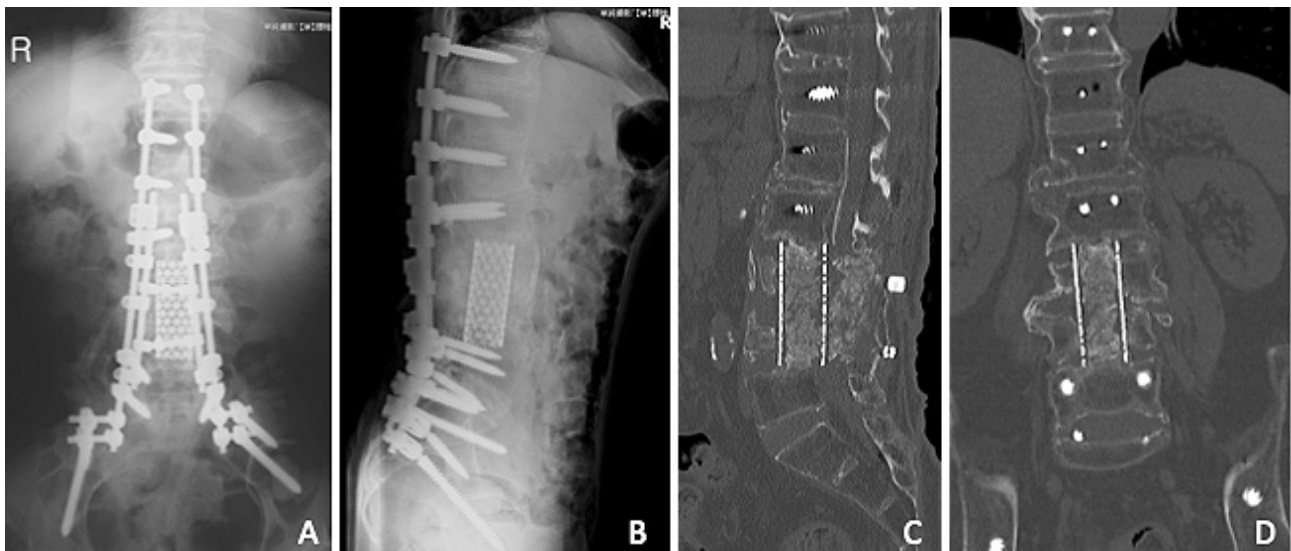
A, B. No implant failures are seen on the X-ray. C, D. Solid bone union is achieved without loosening of screws.
